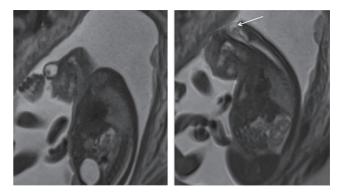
Anencephaly. Fetal MRI scan showing absence of recognisable neural tissue anterior to the upper brainstem (white arrow).
